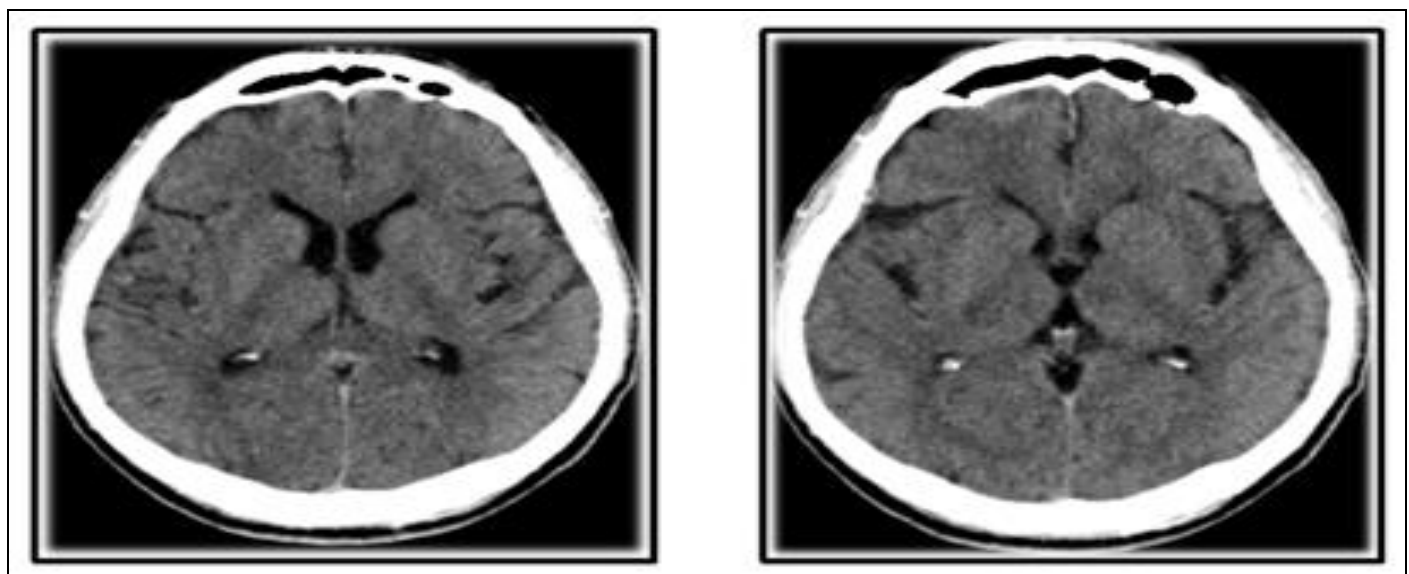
Non-Contrast Cranial CT Scan showing no Hemorrhagic or Ischemic Lesions.
